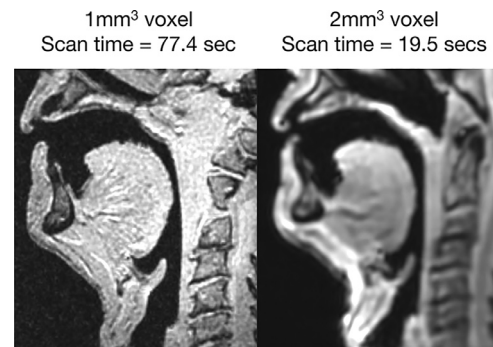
MR image at two resolutions.
